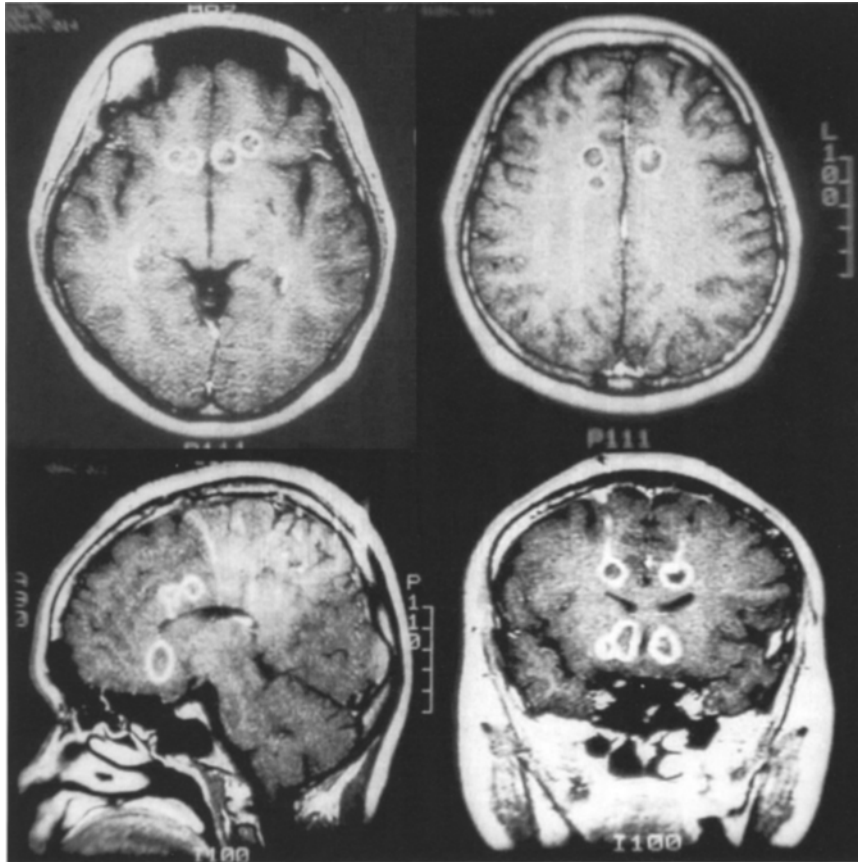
Postoperation MRI after limbic leucotomy. *Note:* Limbic leucotomy which is combined bilateral cingulotomy with subcaudate tractotomy was done for OCD
